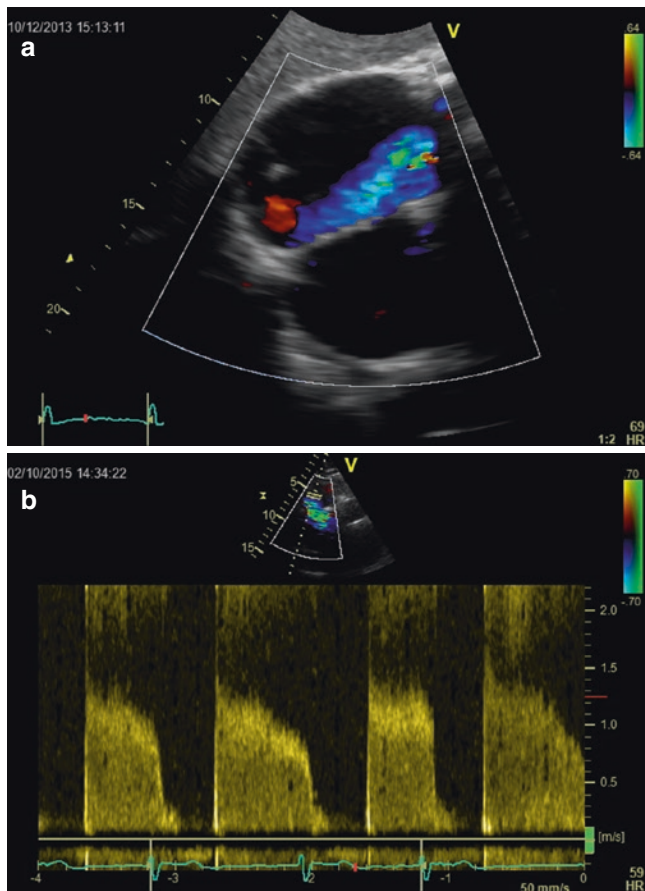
A 73-year-old female patient with Ebstein's anomaly of the tricuspid valve (TrV) presented in NYHA III functional class. After a surgical tricuspid valve plasty, a DDD-pm was inserted in 1995, in 2006 a bioprosthesis (Carpentier-Edwards Perimount 33 mm) was implanted. Now (2015) this prosthesis showed severe regurgitation with subsequent enlargement of the right atrium (a). Additionally, a mean Doppler diastolic inflow gradient of 5–6 mmHg developed over time (b), and the indication for bioprosthetic tricuspid valve replacement for regurgitation and stenosis was assessed. A surgical replacement of the TrV was thought to be associated with an increased risk by the surgical team. A percutaneous tricuspid valve implantation (PTVI) was scheduled
